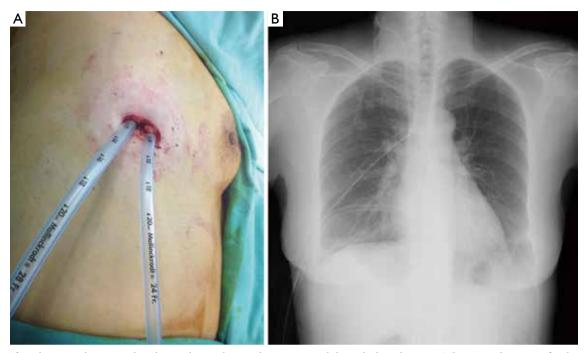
After the procedure, we placed two chest tubes in the respective bilateral pleural spaces. The two tubes were fixed in the same single wound (A). A chest radiograph was taken to confirm their location and function (B).
